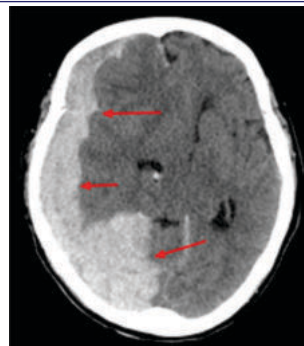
CT Scan In Patient With SDH: Concavo Convex
